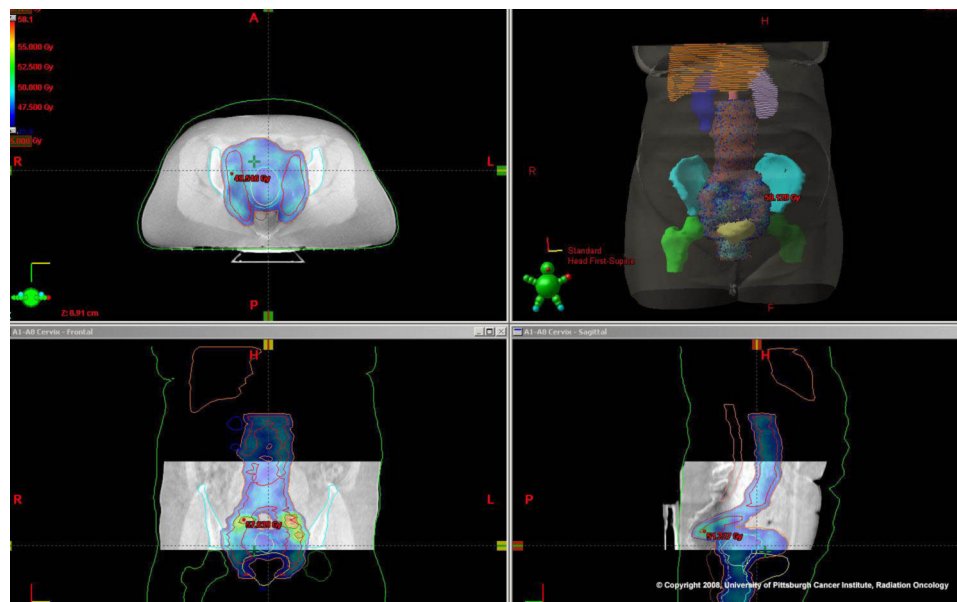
The cone-beam CT with isodose distribution demonstrates the coverage of the extended field. The liver is shown in orange, the right kidney in purple, and the left kidney in pink. *Image courtesy of the University of Pittsburgh Cancer Institute.*
